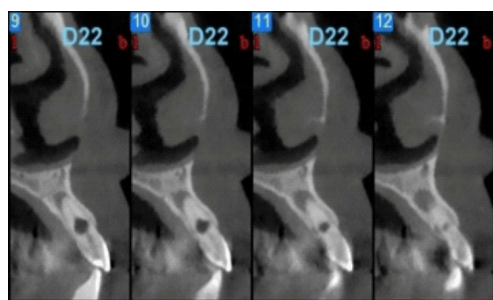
Preoperative CBCT. Sagittal view of the real size of periapical lesion in tooth 22.
